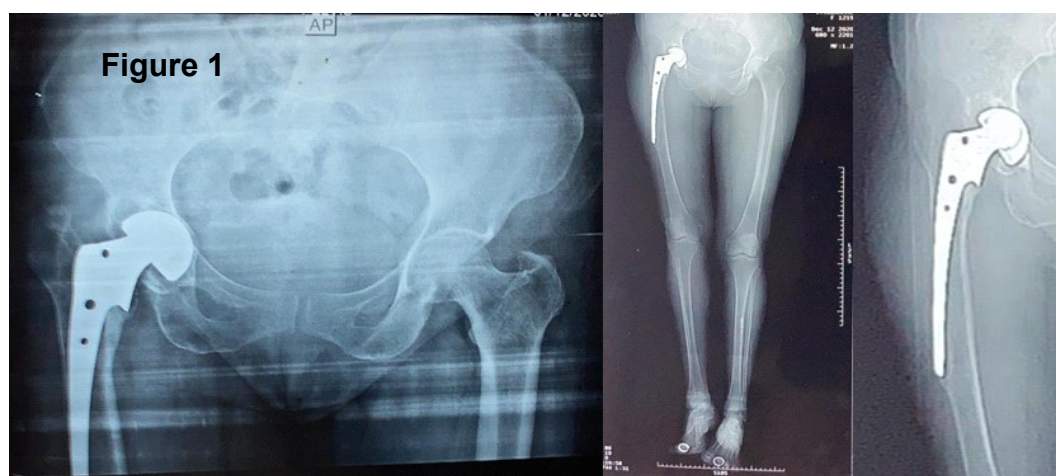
Immediate post op radiograph
